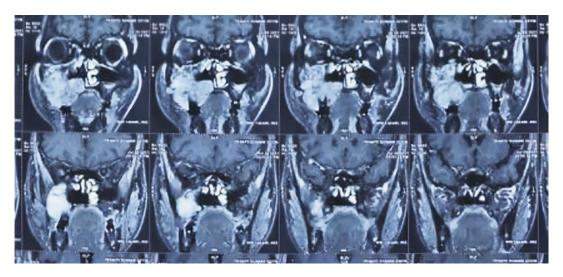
MRI scan showing the lesion in the right maxillary sinus and involving the palate: lesion over the palate is seen crossing the midline anteriorly
